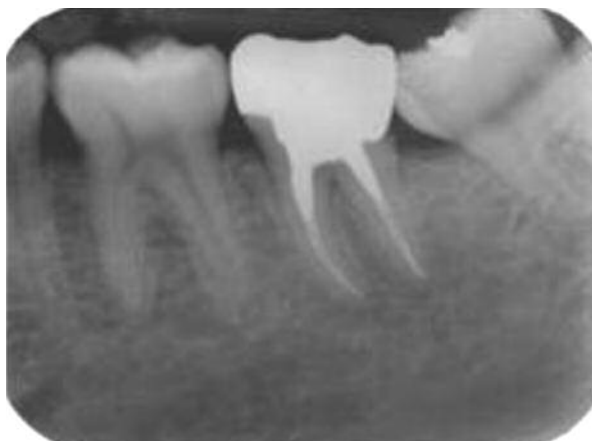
Two years periapical radiograph revealed complete bone formation at the apex and furcation.
